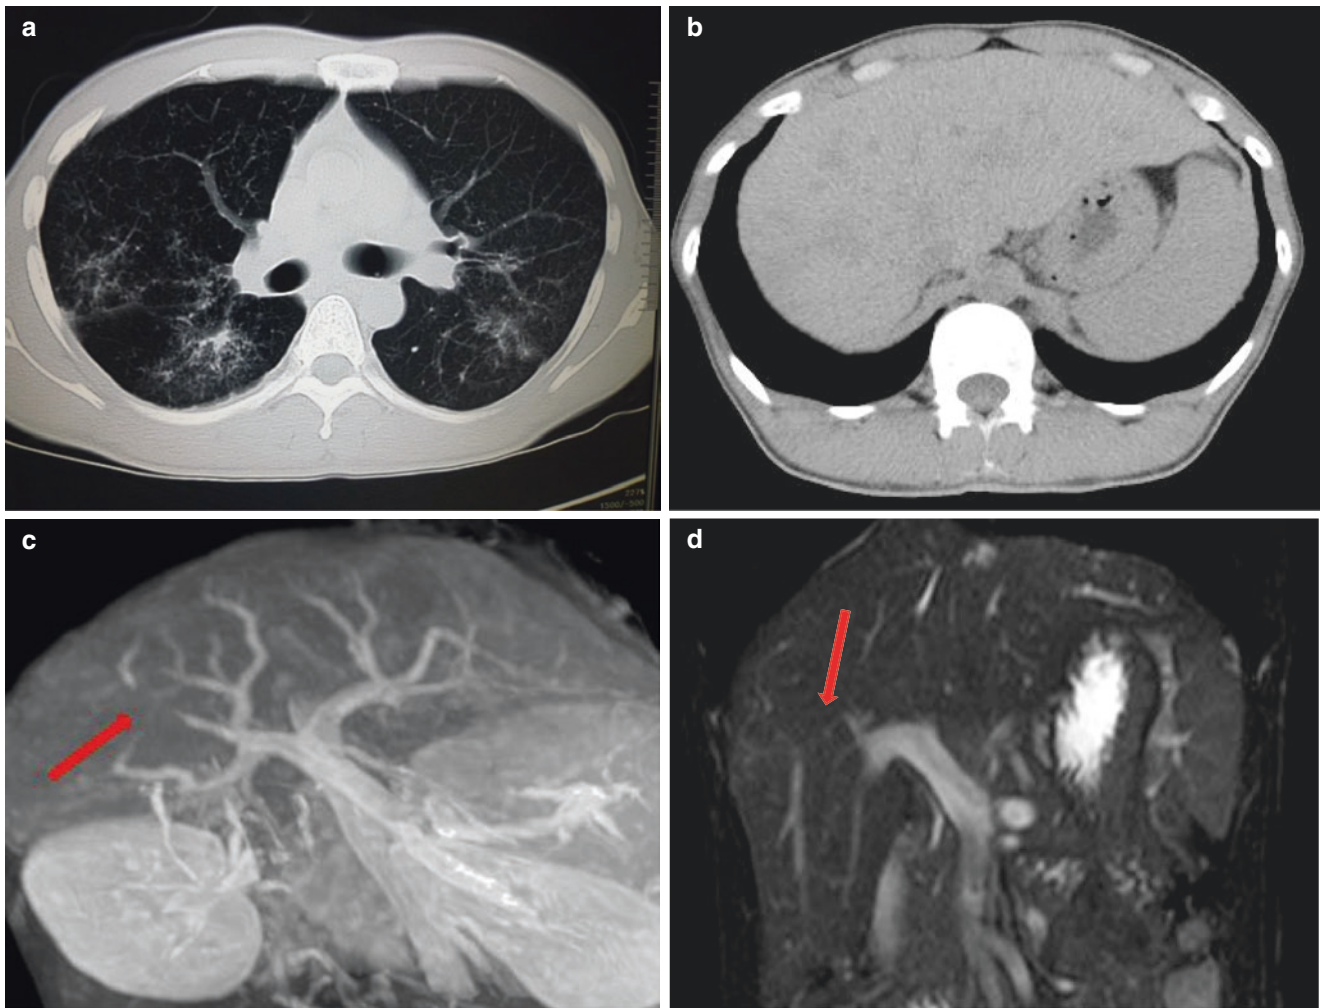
Sarcoidosis. (a) Chest CT shows high-density area in lower field of bilateral lung, and granular shadows are detected. (b) Abdominal CT without contrast medium shows presence of multiple low-density
